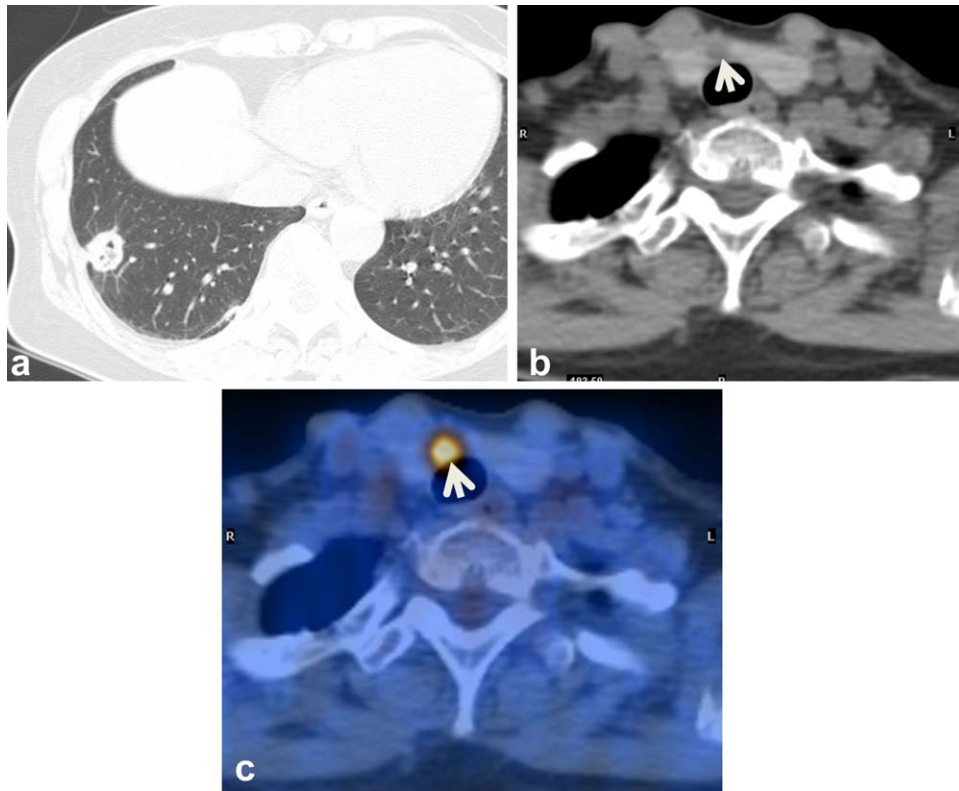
Unexpected cancer detection at PET/CT in a 61-year-old woman who has lung cancer in right lower lobe. A: Lung window of CT scan (5.0-mm section thickness) obtained at liver dome shows a 22-mm size malignant-morphology nodule in right lower lobe which proved to be lung adenocarcinoma. B: CT component image of PET/CT demonstrates a 12-mm size low-attenuation nodule (arrow) in right thyroid gland. C: PET-CT image discloses high glucose uptake within the nodule, which proved to be papillary thyroid carcinoma (PTC).
